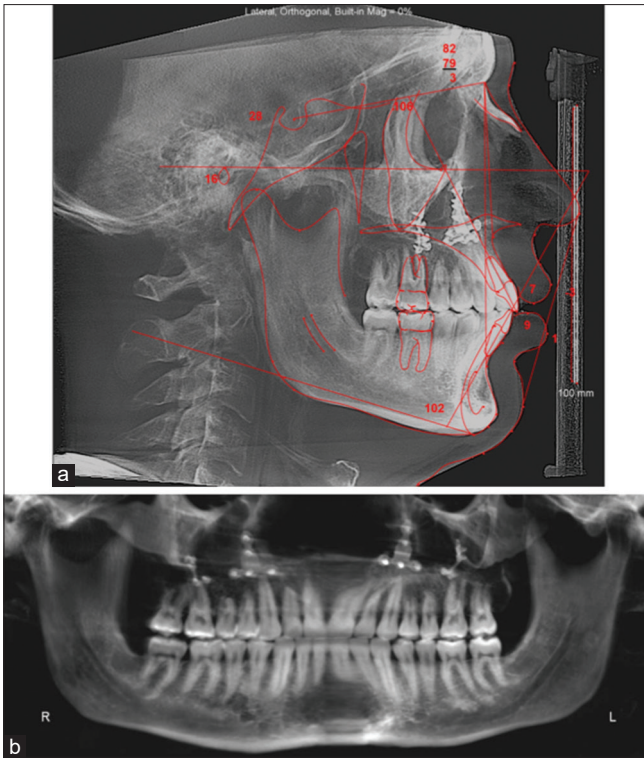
Posttreatment radiographs. (a) Lateral cephalometric radiograph with tracing. (b) Panoramic radiograph
